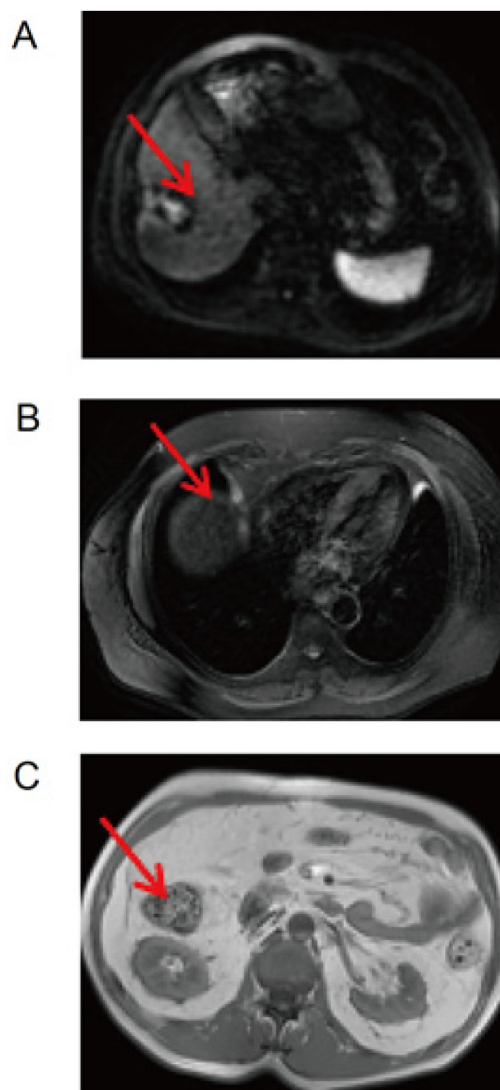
Identification of HCC by dynamic contrast-enhanced MRI. A: The DCE-MRI image of the right lobe of the liver shows a type III lesion with multiple nodules. B: The DCE-MRI image of the right lobe of the liver shows capsule defect of the lesion. C: The DCE-MRI image of the right lobe of the liver shows the presence of patches or crescent-shaped areas around the HCC lesion in the arterial phase and iso- and hypo-intense signals in the portal venous or equilibrium phase. The area marked by the arrows indicates the type of tumor.
